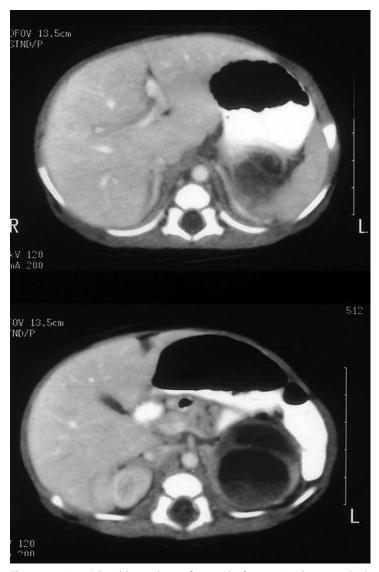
Adrenal hemorrhage often results from perinatal stress or birth trauma. The radiographic appearance showing a left suprarenal heterogeneous mass is suspicious for neuroblastoma.
